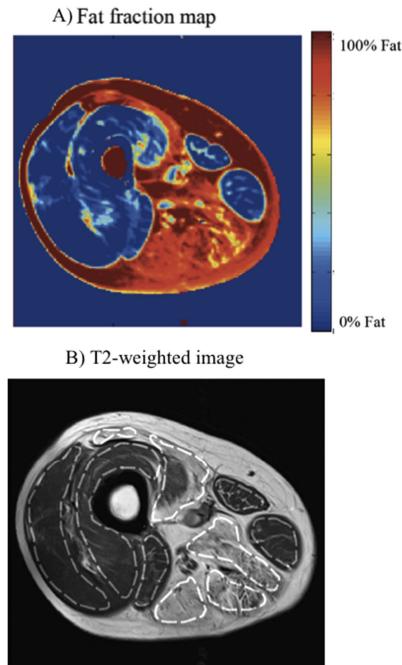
A) Quantitative fat fraction map of a FSHD patient with severe fatty infiltration in the hamstring muscles. Muscular fat fraction ranges from 0 to 100%. B) Corresponding T2-weighted MR image. Regions of interest were carefully drawn on every individual muscle.
